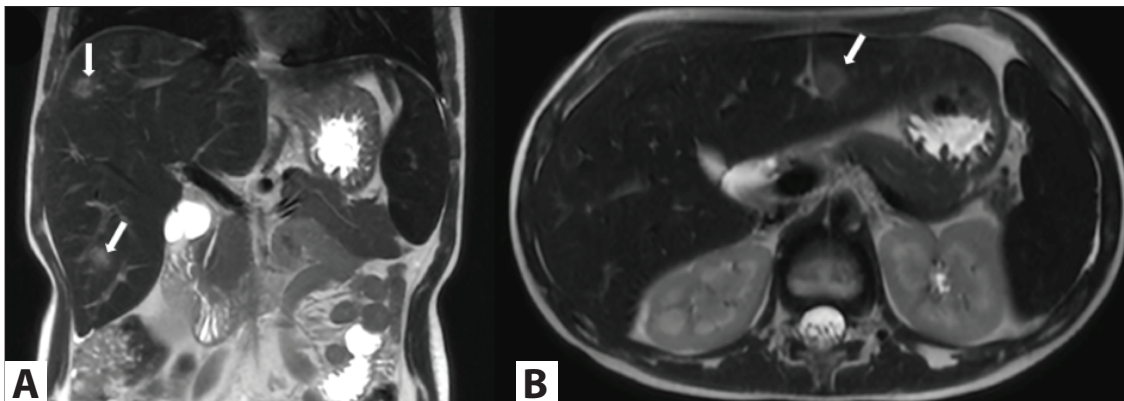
Without fat suppression, coronal (A) and axial (B) T2-weighted images show hyperintense lesions with indistinct borders in the liver (white arrows).
